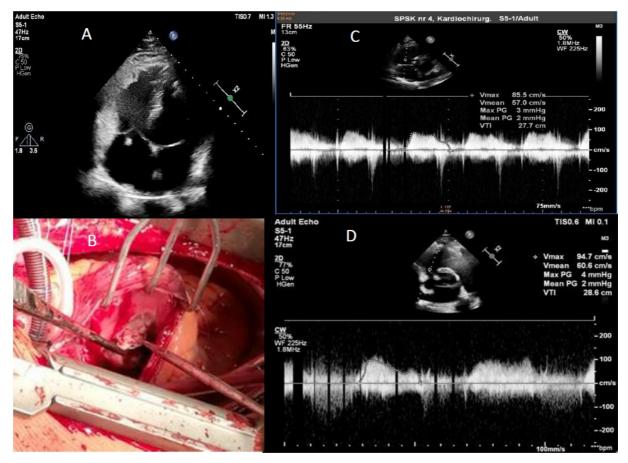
A. Fragment of the papillary muscle in the right atrium — echocardiography image;B. Fragment of the papillary muscle — intraoperative image;C. Discharge echocardiography of the first patient;D. Discharge echocardiography of the second patient
